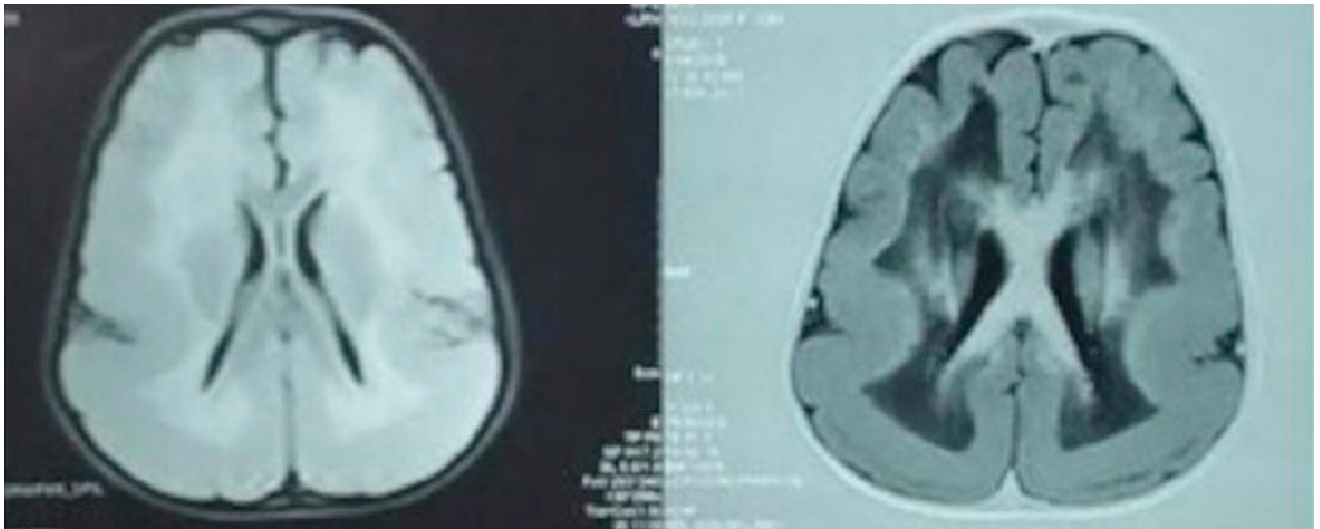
T1 and T2 weighted MR images showing paucity of sulci and gyri, thick cerebral cortex and hypoplasia of corpus callosum suggestive of type 1 lissencephaly
